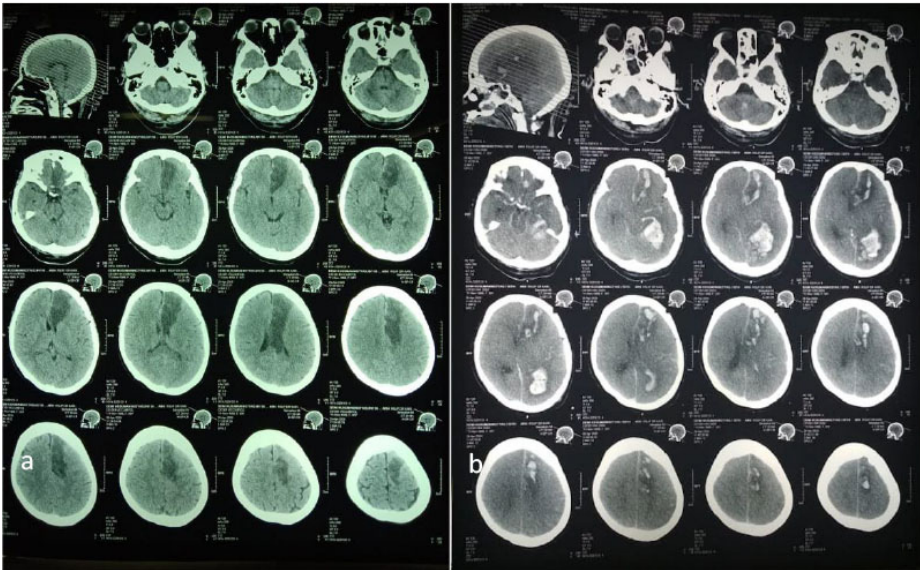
Non-contrast head CT Scan of patient 1 showing (a) extensive left frontal infarction in left anterior cerebral artery territory; (b) extensive hemorrhagic transformation on the site of infarction.
